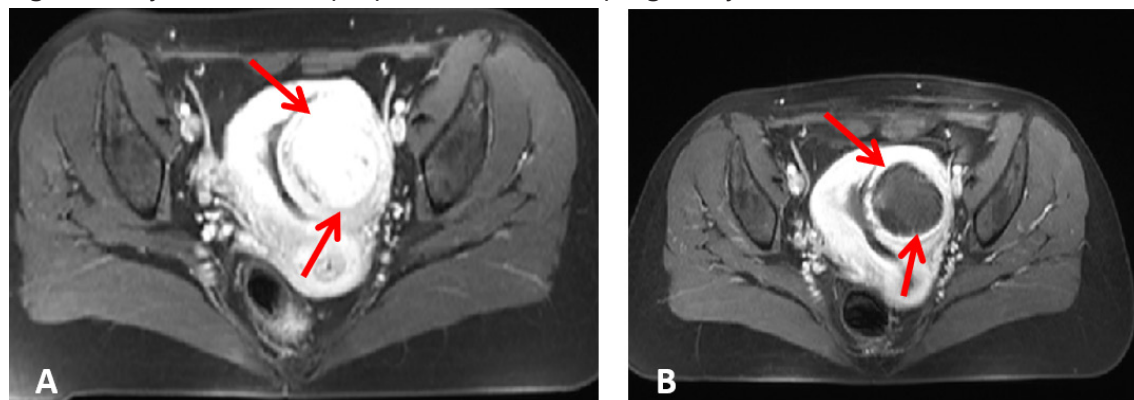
Contrast-enhanced MR images obtained from a 31 years old patient with uterine fibroid who wish to conceive. (A) Pre-HIFU MRI showed a submucosal fibroid (FIGO type II) located in the left lateral wall of the uterus. The size was 5.5 cm in diameter (arrow); (B) one day post-HIFU showed no perfusion in the uterine fibroid (arrow). The fibroid was completely ablated without damaging to the endometrium and adjacent myometrium.
